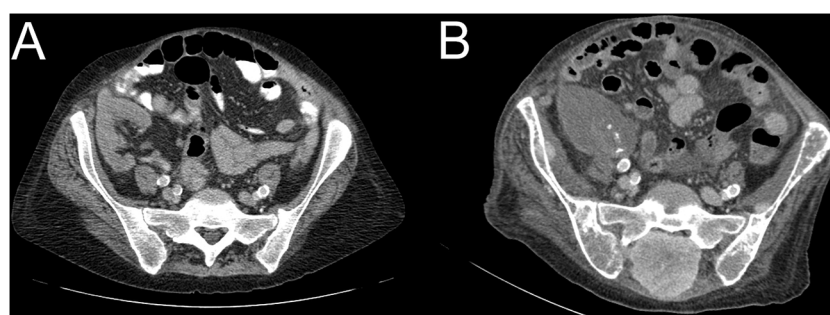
Axial CT images through the pelvis taken 3 years apart. (A) A renal transplant is noted in the right iliac fossa and appears within normal limits. The visualised sacrum and ilia are unremarkable. (B) There is loss of cortico-medullary differentiation in keeping with a failed renal graft. A soft tissue mass is seen in the dorsal aspect of the sacrum which extends into the sacral canal. Note decreased mineralisation in the iliac wings in keeping with osteomalacia.
